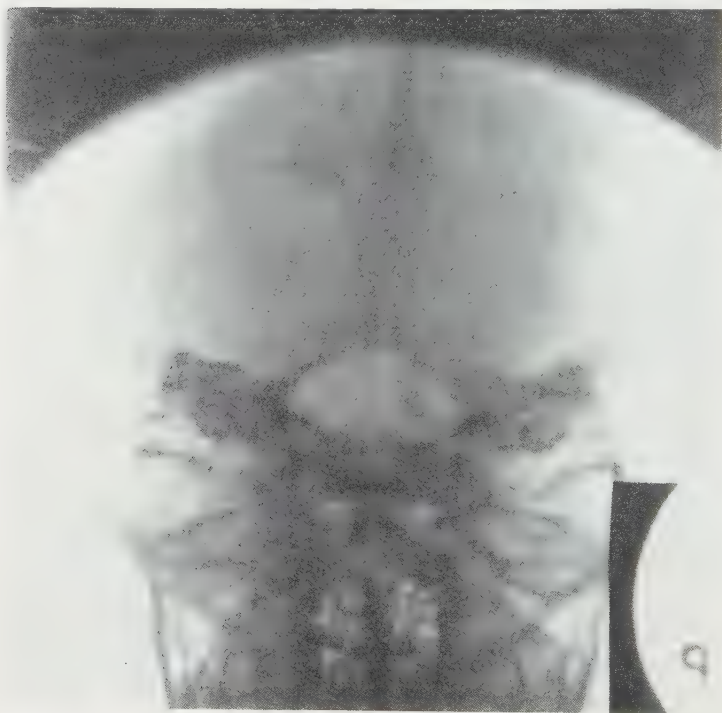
Anteroposterior roentgenogram, the rays directed so that the clinoid processes are viewed through the foramen magnum. Calcification can be seen in the right wall of a sellar and suprasellar craniopharyngeal duct cyst. The patient was a girl of six years.
